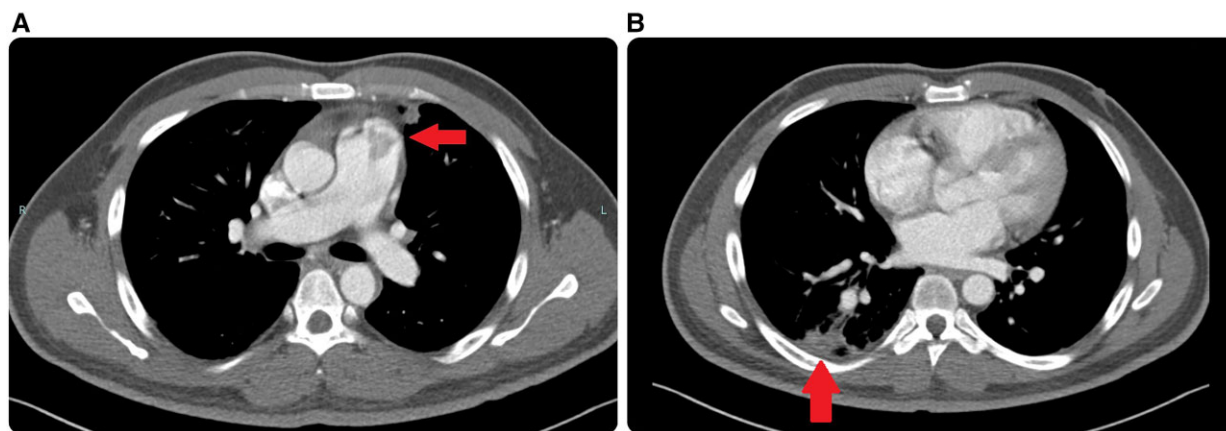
(A) Computed tomography pulmonary angiogram (CTPA) showed vegetation within the main pulmonary trunk, attaching to the pulmonary valve leaflets (red arrow), (B) Pulmonary consolidation at posterobasal segment.
